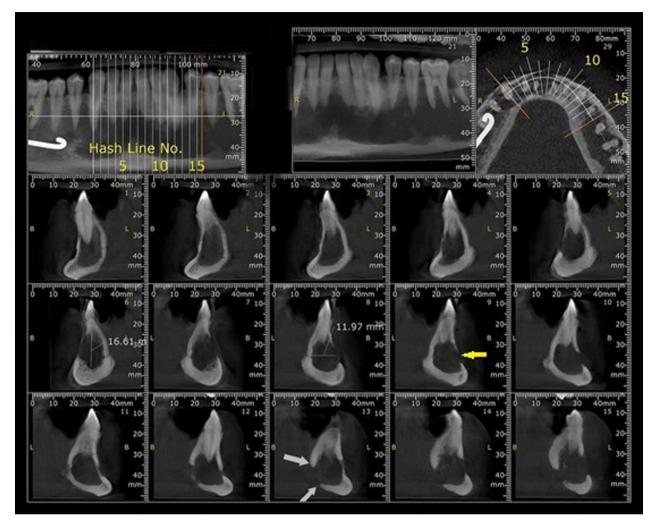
Cross sectional cuts of anterior mandible in cone beam computed tomography. The perforation is evident in buccal cortex (yellow arrow) and lingual cortex (white arrows)
